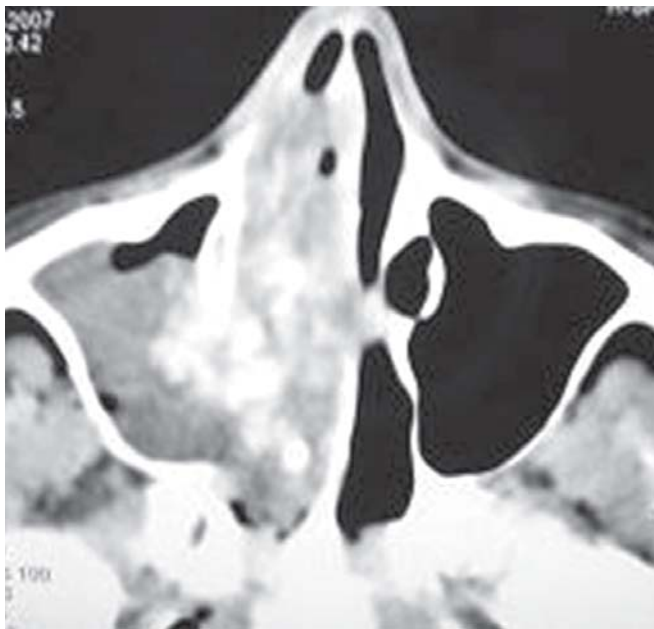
Axial CT – PNS showing the characteristic 'double-density' sign, in a patient with right sided AFRS
